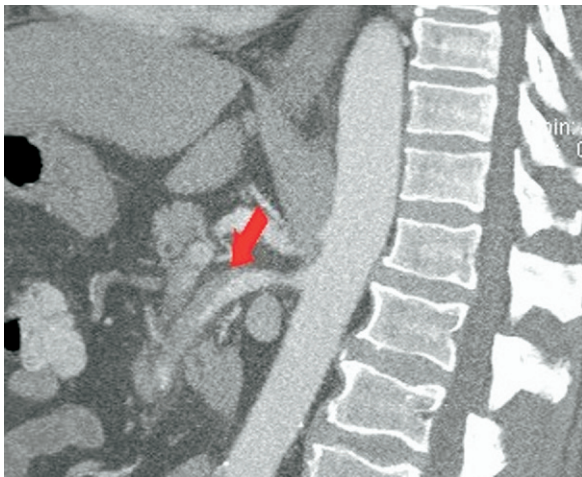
Sagittal computed tomography reconstruction shows proximal superior mesenteric artery dissection and unopacified false lumen (*arrow*).
